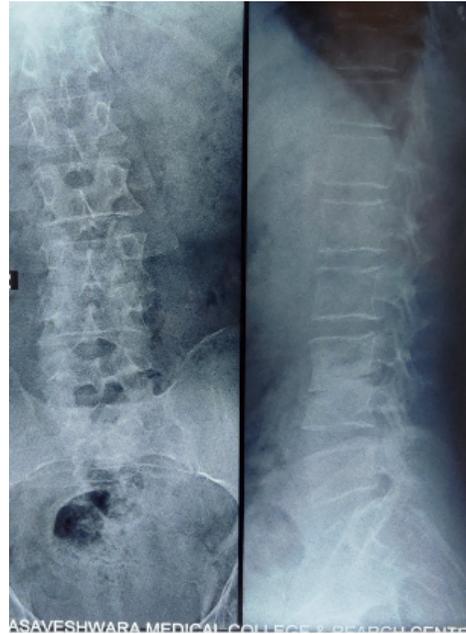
X-Ray LS Spine AP and Lateral
